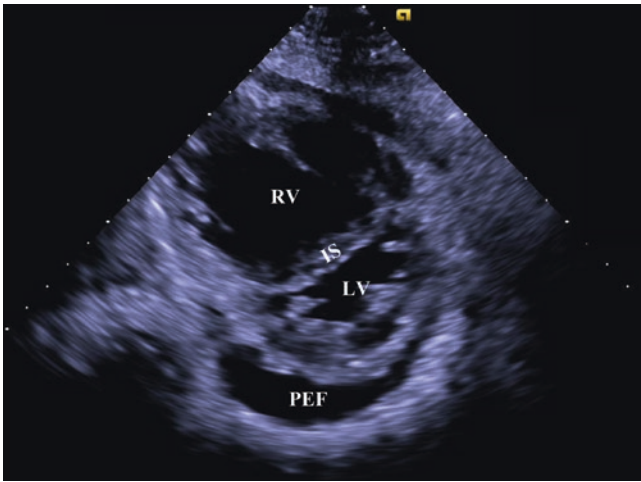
The parasternal short axis view in a patient with shortness of breath. The right ventricle (RV) is dilated while the left ventricle (LV) appears small and hyperdynamic. The interventricular septum (IS) is flattened making the left ventricle D-shaped instead of the normal round shape. Pericardial effusion (PEF) is also seen. This patient has pulmonary hypertension with right ventricular failure. See also Video 16.4
